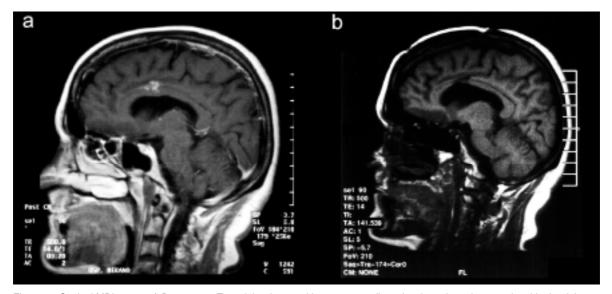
Sagittal MRI scans. a) Pre-surgery T1-weighted scan with contrast medium showing a hyperintense signal in the right gyrus cinguli. The examination was performed on January 27th, 1999 at Merano City Hospital. b) Post-surgery T1-weighted scan without contrast medium showing a hypointense signal in the posterior part of the ACC. The examination was performed on June 26th, 1999 at Bolzano City Hospital.
